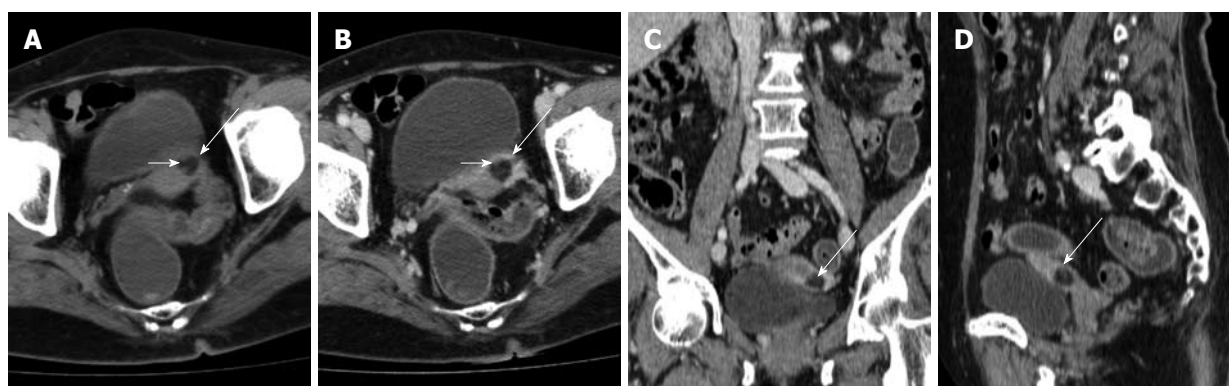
Computed tomography images of uterine lipoma in a 72-year-old woman. A and B: Axial computed tomography images without contrast (A) and after intravenous contrast (B) show a non-enhancing hypodense lesion (long arrows) in left side of the uterine fundus. Small amount of soft tissue density (short arrows) is noted inside the lesion; C and D: Coronal (C) and Sagittal (D) reformatted images also reveal the relationship of the lesion with the uterus.
